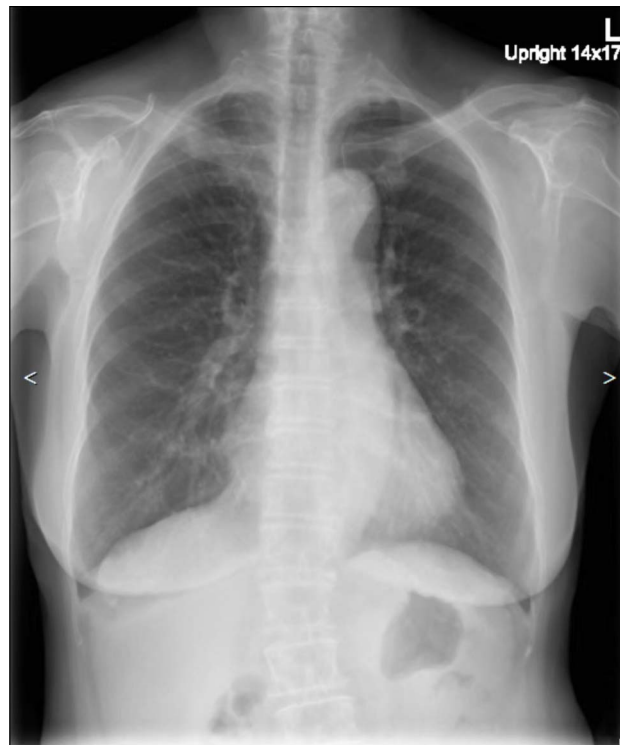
Chest x-ray posteroanterior upright showing a reticular-ground glass at right upper lung zone, which was barely detectable.
